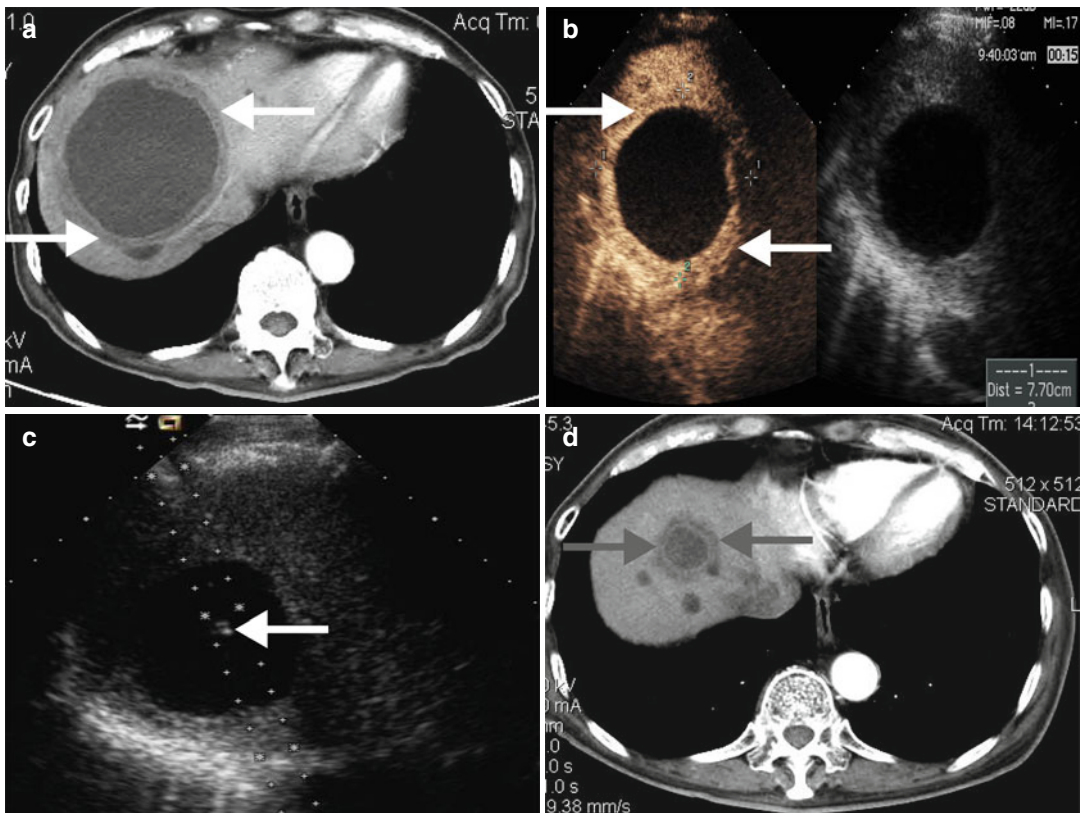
An 81-year-old man with cystic-solid mixed liver metastases from duodenum stromal tumour treated with MWA. (a) Preablation-enhanced CT image shows a cystic-solid mixed lesion (*white arrows*); (b) contrast-enhanced ultrasound shows rim-like hyperenhancement in the solid part of the lesion (*white arrows*); (c) before
